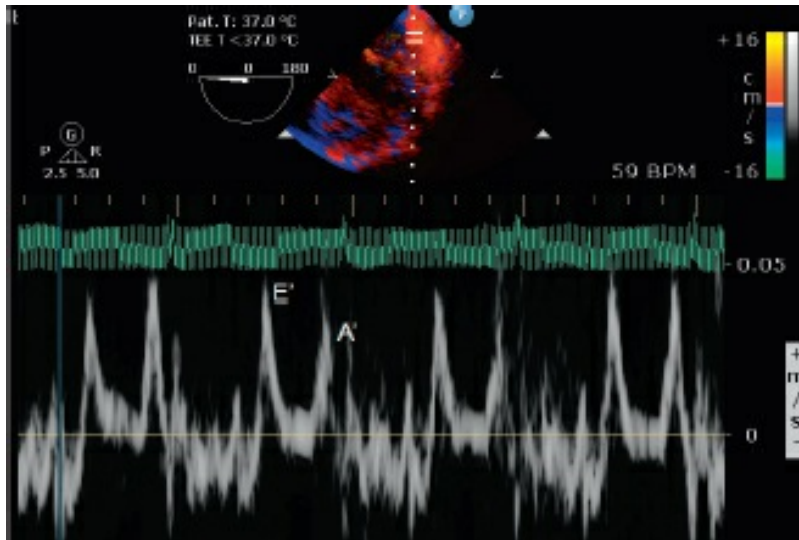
Mitral annular tissue Doppler velocities showing early (E') and late (A') diastolic velocities.
